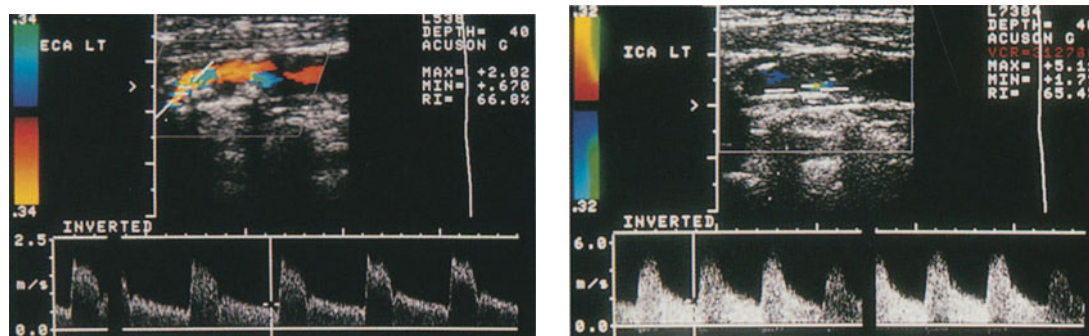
(left). Longitudinal sonogram of carotid bifurcation and ICA shows calcified plaques in carotid bulb and origin of ICA. Spectral tracing shows angle-corrected peak systolic and end-diastolic velocities of 2.02 and 0.67 m/sec. This corresponds to a grade 3 (60–79%) stenosis (see Table p. 49)
